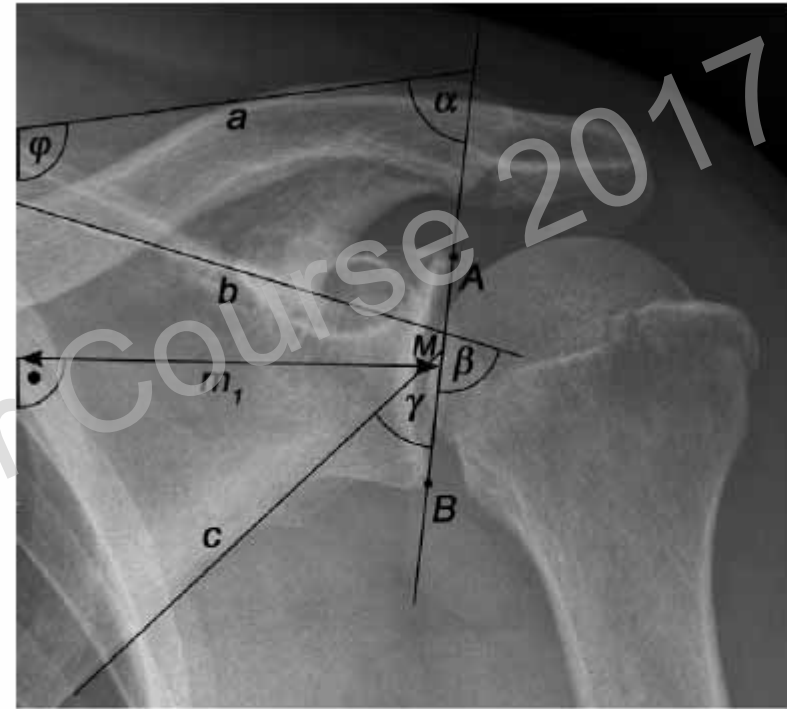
Definition of angles on conventional radiographs. The glenoid fossa line (AB) is defined as a line connecting the uppermost point (A) and the lowermost point (B) of the glenoid. Angle α is the angle between the spine of the scapula (a) and glenoid fossa line (AB). Angle β is the angle between the floor of the supraspinatus fossa (b) and the glenoid fossa line (AB). Angle γ is the angle between the lateral margin of the scapula (c) and the glenoid fossa line (AB). The distance from the medial border of the radiograph and the center of the glenoid fossa line (AB) is m_1 . The angle between the scapular spine (a) and the medial border of the radiograph is ϕ .
